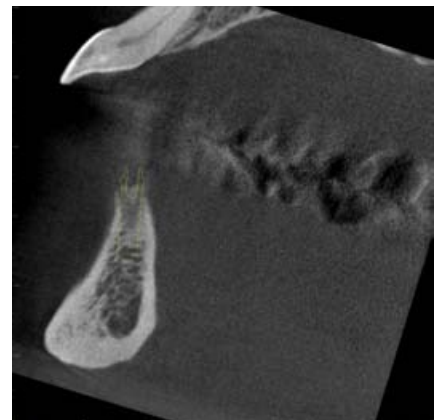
Sagittal CBCT image for implants in the position of the right lateral incisor
